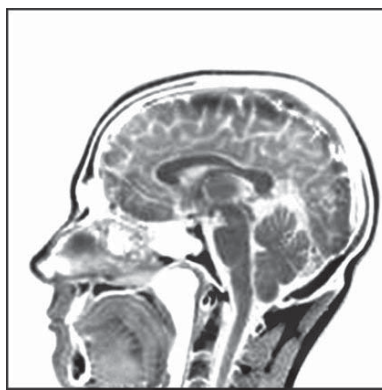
Magnetic Resonance Image Showing a Median Sagittal Cross Section Through a Human Head.
